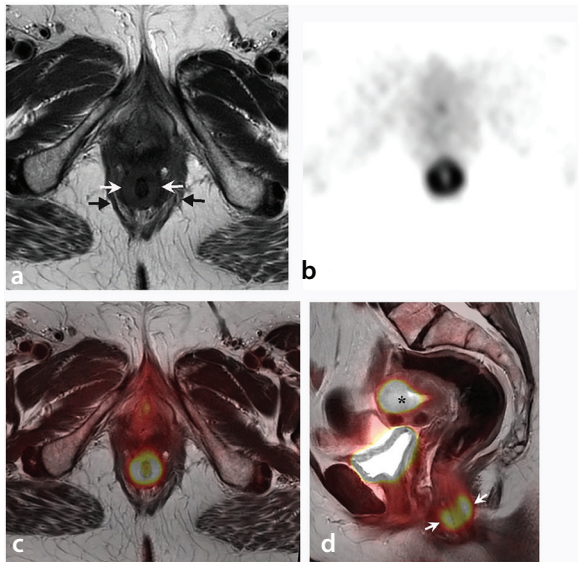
Physiological fluorodeoxyglucose (FDG) uptake in the internal anal sphincter (IAS). The axial T2-weighted image (a) shows the normal IAS with slightly higher signal intensity (white arrows) than the external anal sphincter (black arrows). The axial positron emission tomography (PET) (b) and axial fused PET/magnetic resonance images (MRI) (c) show physiological uptake in the normal IAS. High FDG uptake may indicate high *metabolic* activity in the IAS due to its basal tone, which is fundamental for anal continence. The sagittal fused PET/MRI (d) shows intense physiological FDG accumulation in the distal IAS. An asterisk indicates concurrent endometrial cancer.
